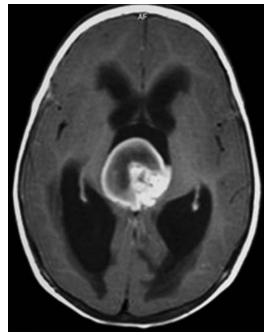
Case 7. Axial Gd-enhanced MR image showing a pure mature teratoma in the pineal region, with the typical association of a solid and a cystic component and well-defined margins.
